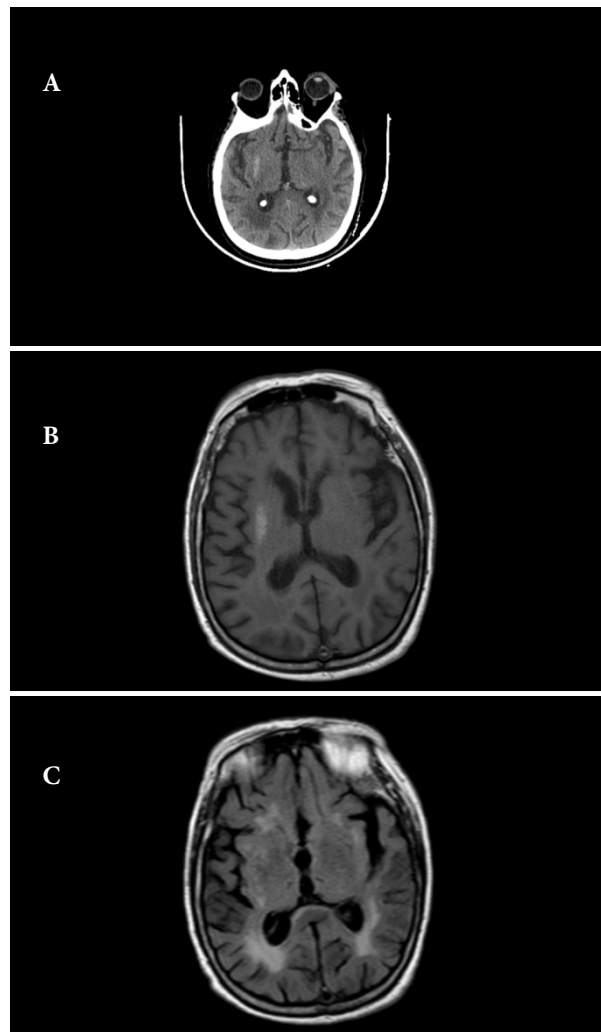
(A-C) (A) Control CT image showing the decrease in the size of hyperdense lesion in the right basal ganglia. (B-C) Control brain MRI (T1 weighted image: B, FLAIR image: C) showing slight decrease in abnormal signal intensities.
